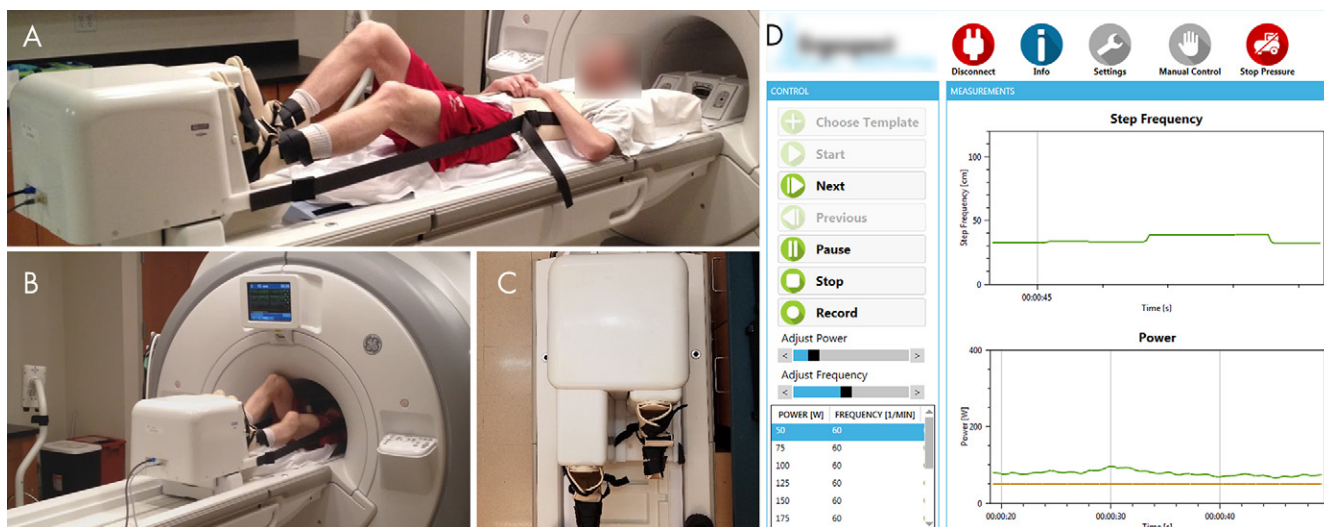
A, Photograph shows the participant set-up for the MRI-compatible exercise stepper. The participant is attached to the stepper with boots with hook and loop fastener straps. A chest harness connected to the stepper minimizes bulk motion during exercise. The strap lengths can be altered to adjust the participant's positioning on the table. B, Photograph shows the participant exercising in MRI bore. C, Photograph of the frontal view of the stepper shows the dynamic range of stepper pedals. D, Screenshot of monitoring software shows the real-time measurements of step frequency and power during exercise.
